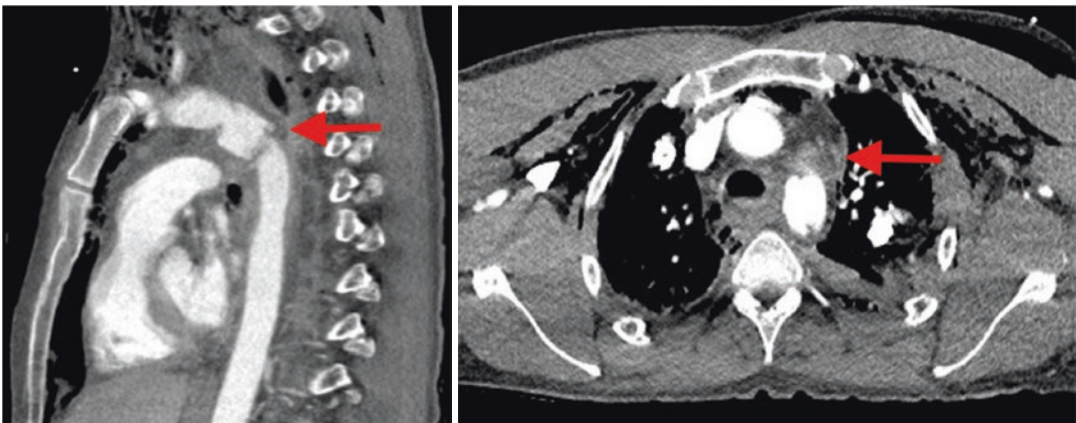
Sagittal and axial contrast enhanced CT images showing a proximal descending thoracic aortic incomplete transection (left) with a resultant mediastinal haematoma (right)
